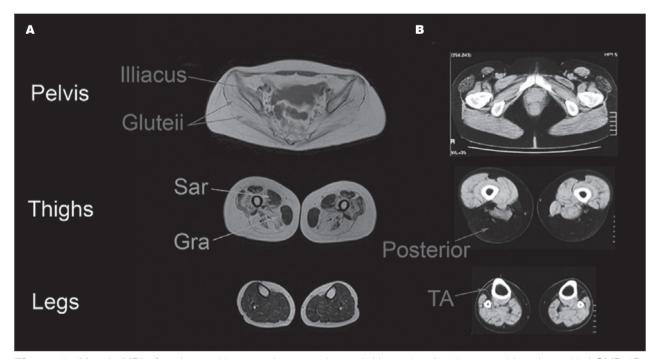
Muscle MRI of patients with sarcoglycanopathy and titinopathy. A: 35 years old patient with LGMD-2D: there is a severe involvement of pelvic muscles (including glutei and psoas muscles) and thigh muscles. Sartorius (sar) and gracillis (gra) are not involved until advanced stages of the diseases. In contrast leg muscles are not involved. B: Muscle CT of a 62 years old patient with distal titinopathy: preferential involvement of the tibialis anterior (TA) and the posterior muscles of the thighs is observed. In contrast, the pelvis muscles are not involved.
